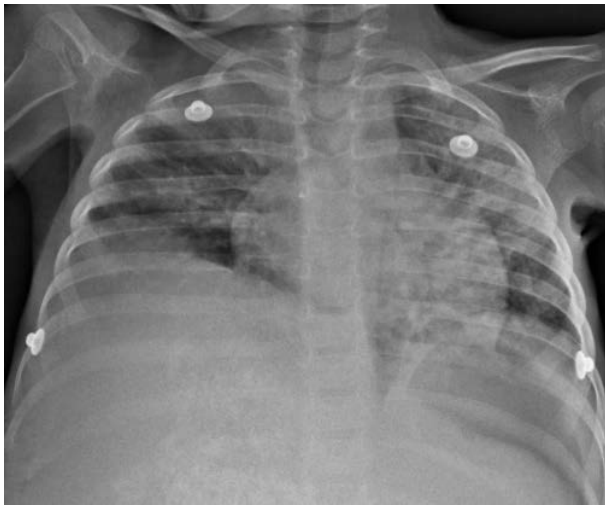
Chest radiograph during HFNC use
